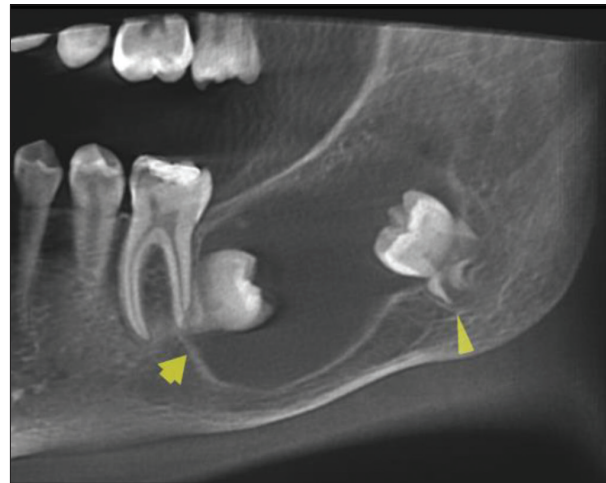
Panoramic reconstructed cone-beam computed radiographic image show dentigerous cyst; a well-defined radiolucent posterior unilocular, pericoronal lesion in the left side of mandible
